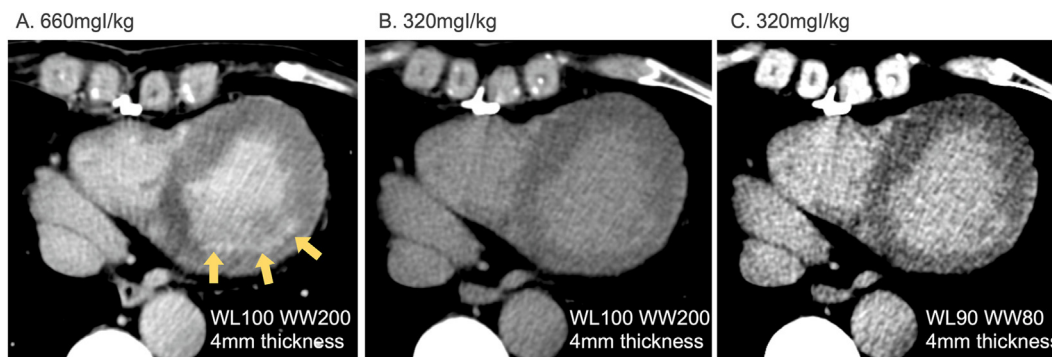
CT-LE imaging obtained with 660 mgI/kg (A) and 320 mgI/kg (B, C) of iodine-based contrast medium in patient with a history of myocardial infarction. Subendocardial infarction is clearly visualized in the lateral wall with 660 mgI/kg (A), but is difficult to discern with 320 mgI/kg at the same window setting (B) or with a narrowed window setting (C). CT-LE, computed tomography late enhancement.
